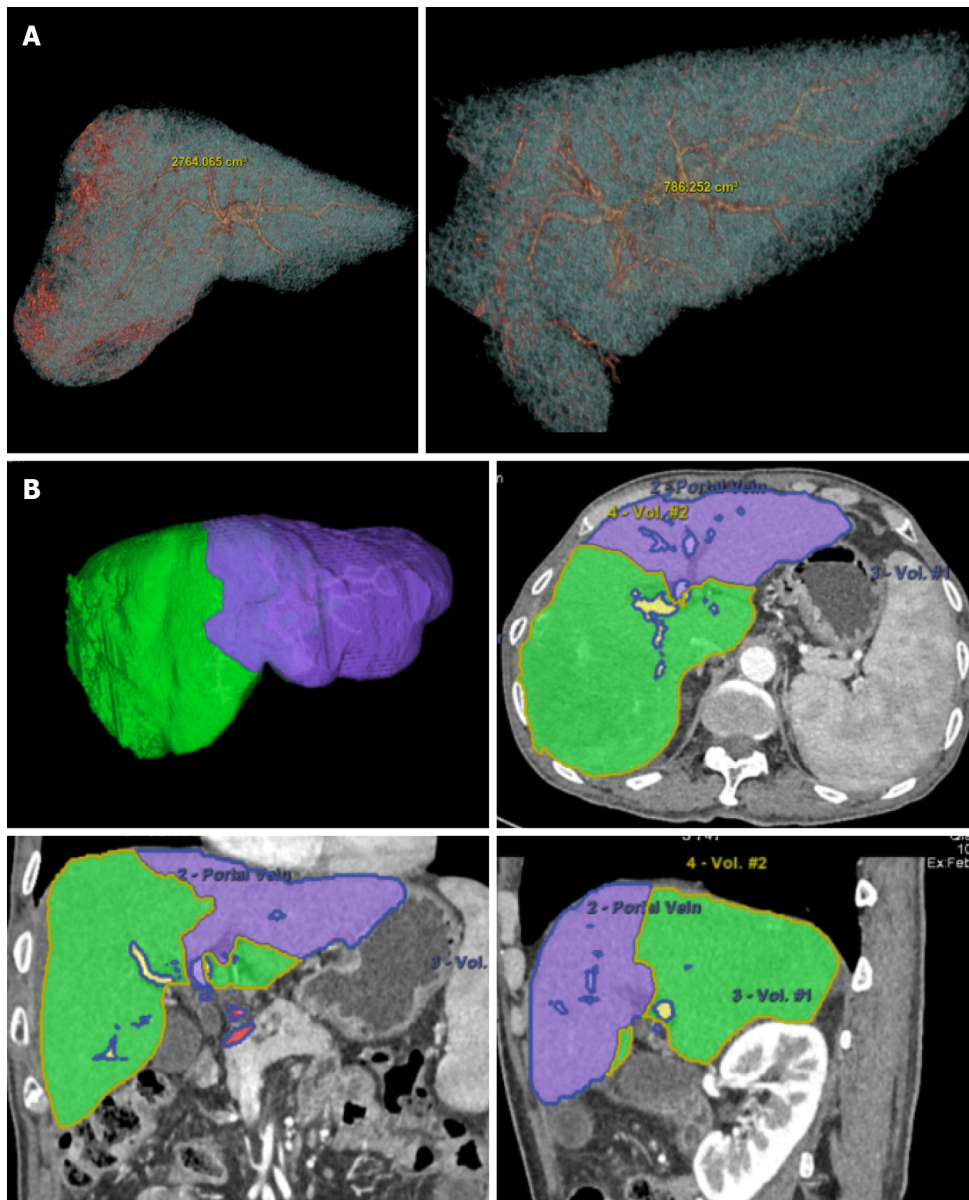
Three-dimensional computed tomography reconstruction of the liver and volume calculation. A: The total liver volume was 2764 cm³ and the residual was 786 cm³ before treatment; B: After three months of conversion therapy, the total liver volume was 1975 cm³ and the residual was 650 cm³.
